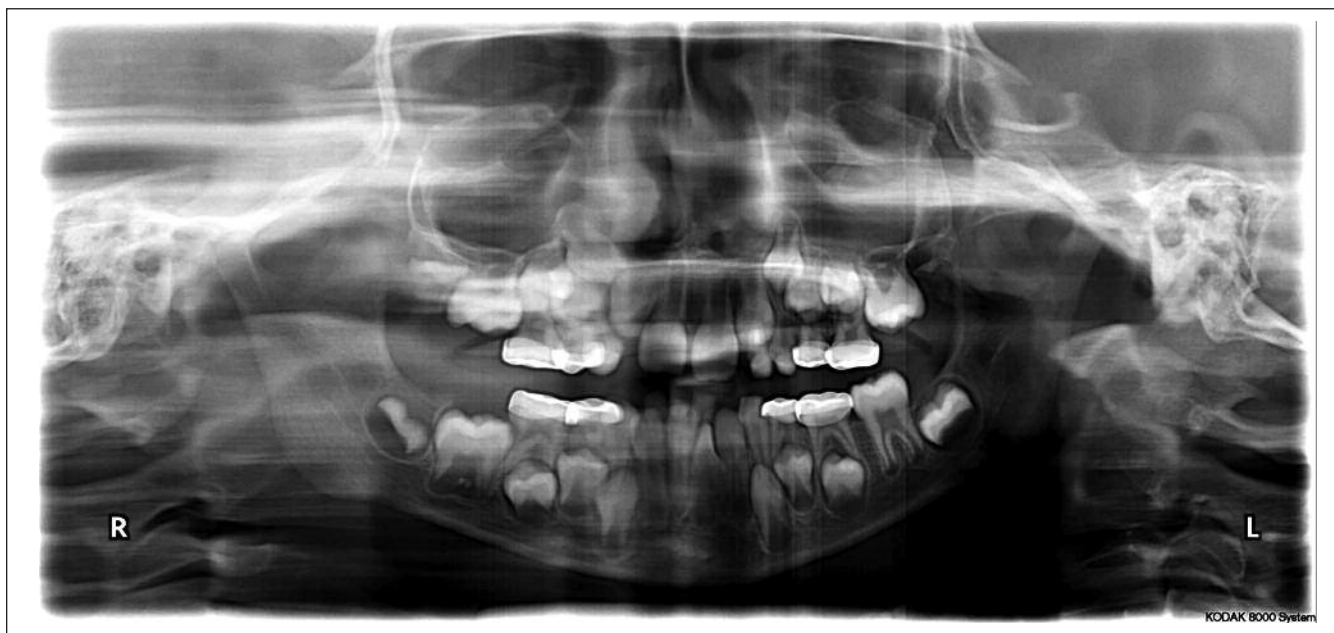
Orthopantomograph at 7 years of age
